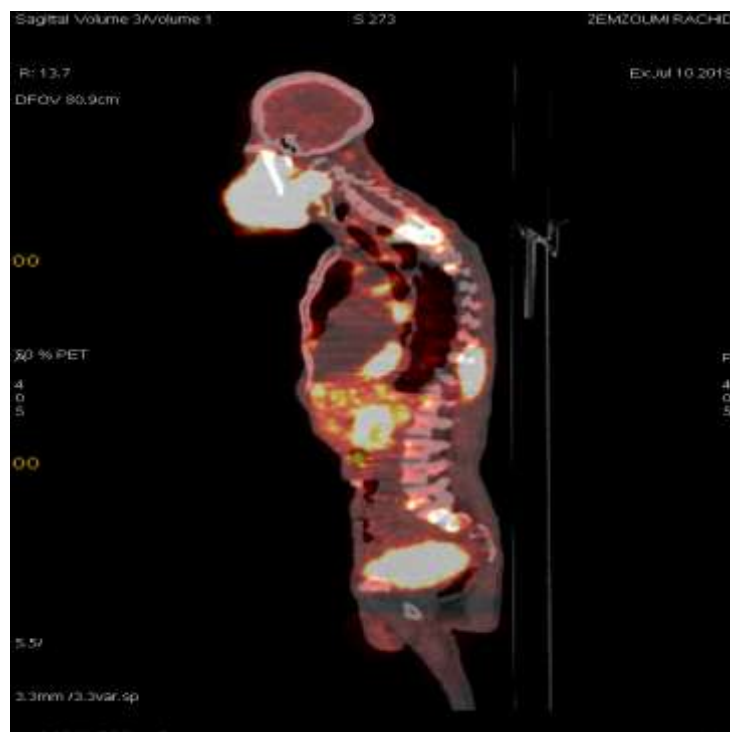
FDG-PET-Scan (sagittal plane), showing a voluminous left mandibular hypermetabolic mass , supra and sub diaphragmatic lymph nodes hypermetabolism , pulmonary nodules , involvement of the left pleura, lever , spleen , bone and bilateral adrenal parenchyma (stade IV).
